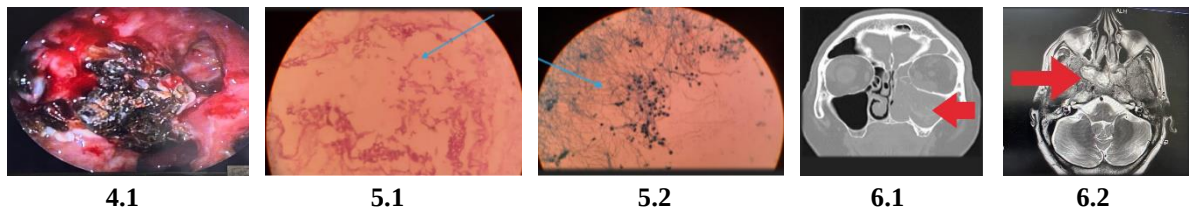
Nasal endoscopy shows Black eschar formation in the right nasal cavity with mucosal destruction. Figure 5.1. Broad, aseptate, hyaline fungal hyphae with right angle branching suggest mucormycetes. Fig: 5.2 Septate hyphae with acute angle branching suggestive of aspergillum. Figure 6.1. The coronal cut of the CT scan shows complete opacification of the left maxillary sinus with areas of hyperattenuation, which is suggestive of fungal concretions. Figure 6.2. Saggital cut a MRI scan showing fungal concretions in the bilateral posterior ethmoids and sphenoid sinus.
